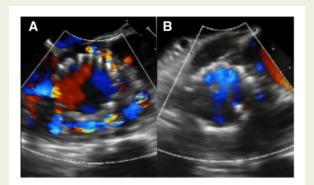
Pre- and post-transoesophageal echocardiography short-axis view for valve-in-valve transcatheter aortic valve replacement. (*A*) Pre-transoesophageal echocardiography short-axis view. (*B*) Post-transoesophageal echocardiography short-axis view. Following valve-in-valve transcatheter aortic valve replacement, paravalvular leak was significantly improved.
